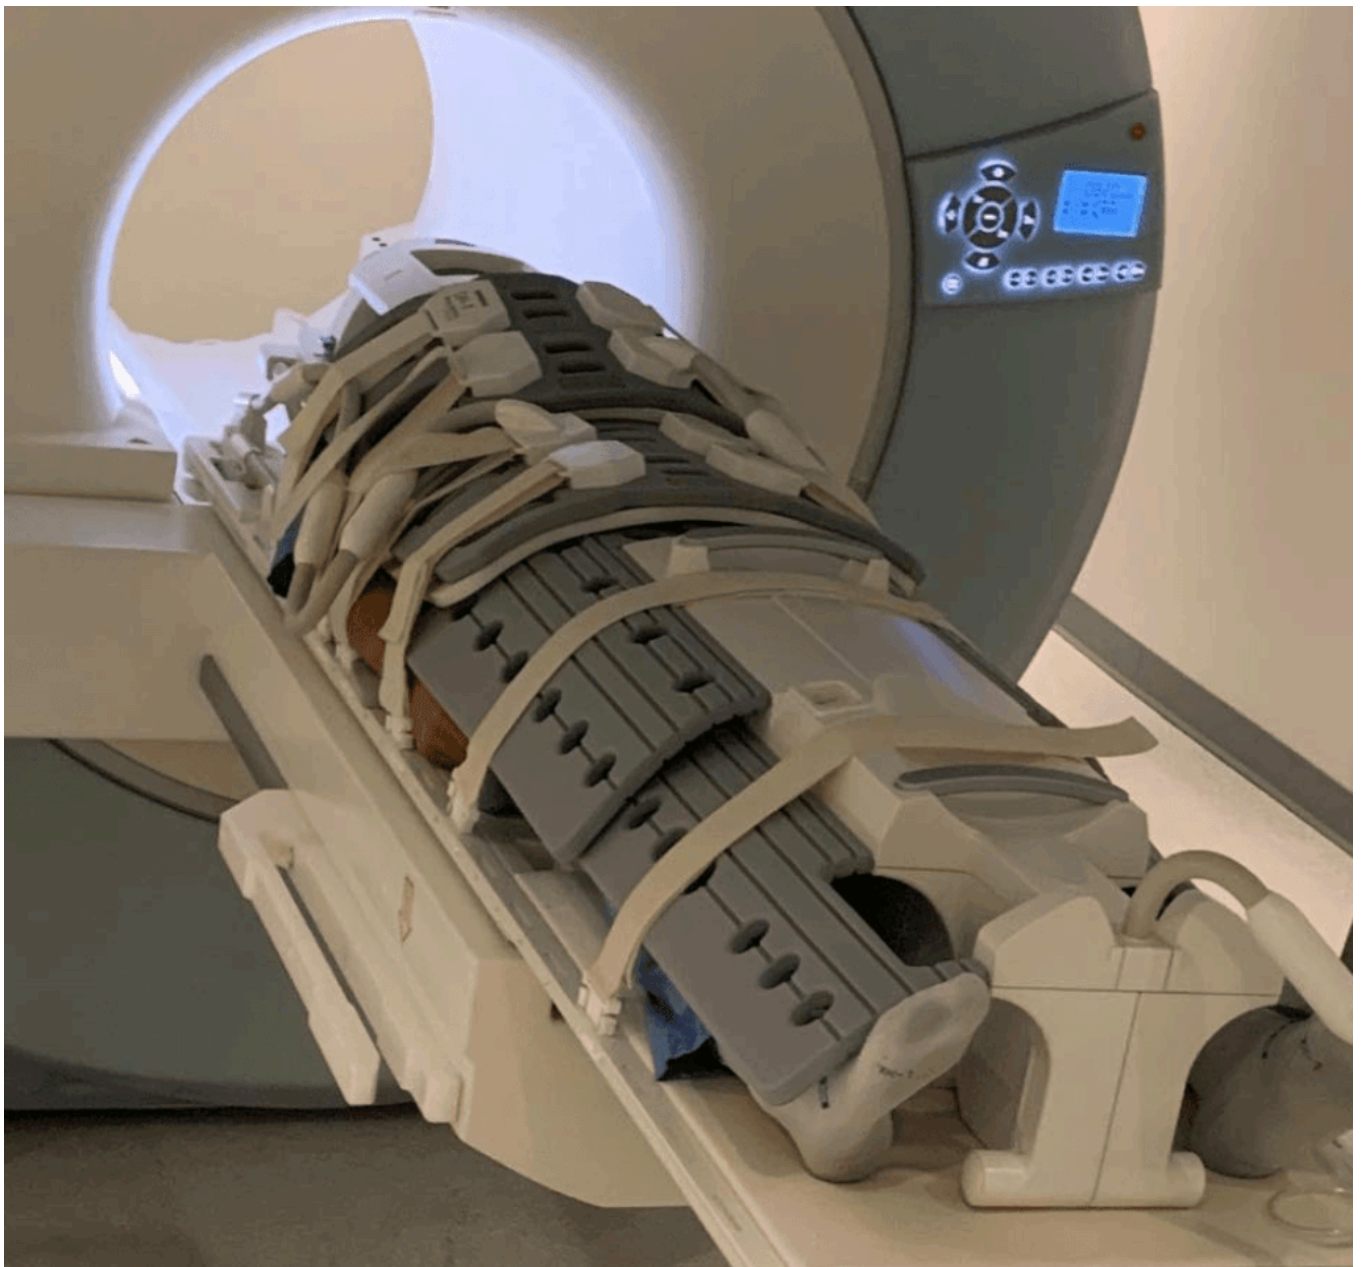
Peter going into a Penuvo MRI machine for a whole-body MRI. Image credit: [#61 – Rajpaul Attariwala, M.D., Ph.D.: Cancer screening with full-body MRI scans and a seminar on the field of radiology.](#)
